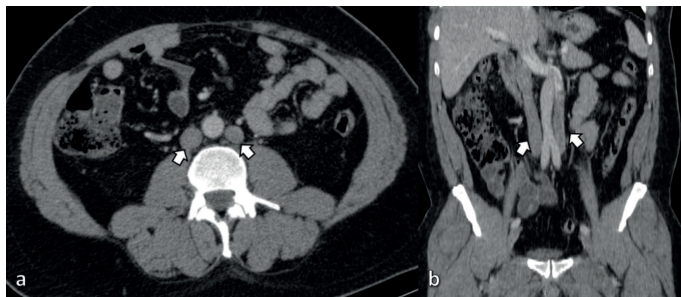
On axial and coronal contrast enhanced abdomen CT images (a, b) you can see duplicated inferior vena cava (white arrows).
